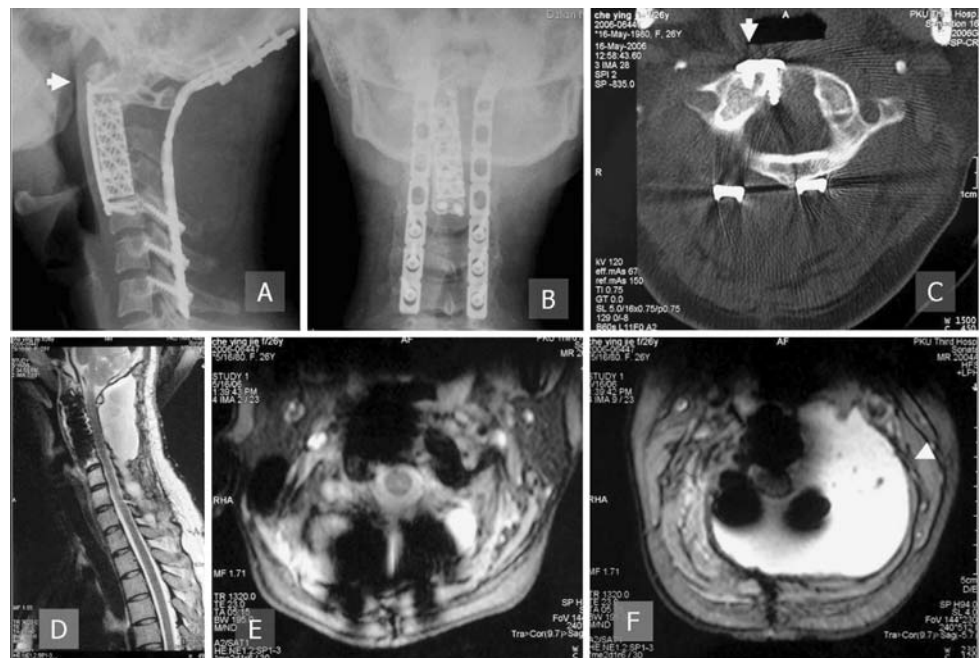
Postoperative image at 3 year follow-up. a, b X-rays, c axial CT of C1, d sagittal MRI, e, f axial MRI of C2 and C3
